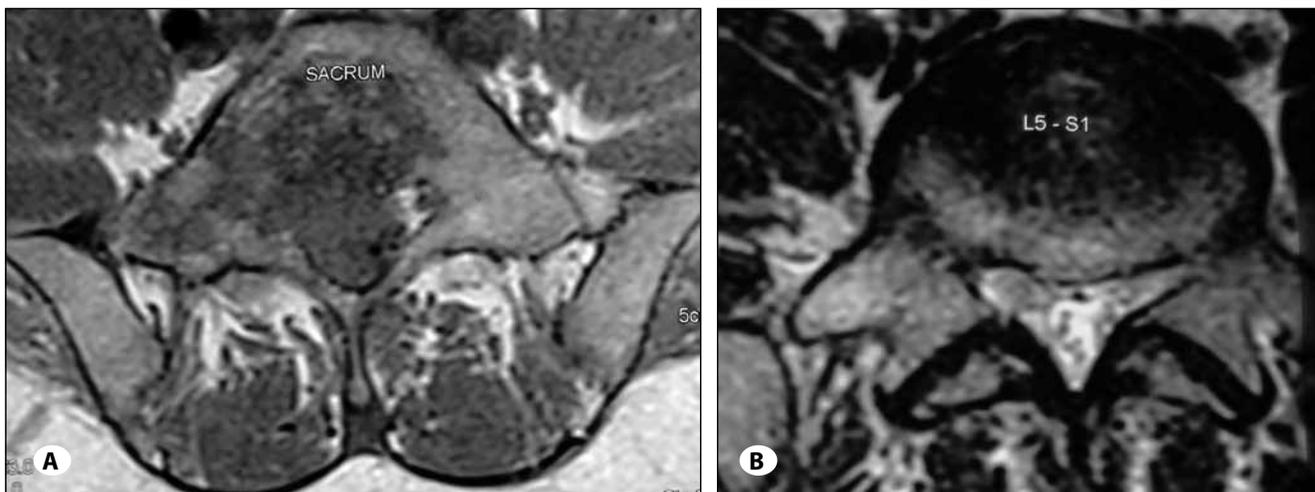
MRI scan of lumbosacral spine A) T1-weighted axial sections reveal isointense signal changes in sacrum with breach in the posterior cortical margin of the bone with soft tissue extension causing root compromise on right side B) T2-weighted axial sections reveal hyperintense signal changes in sacrum.
